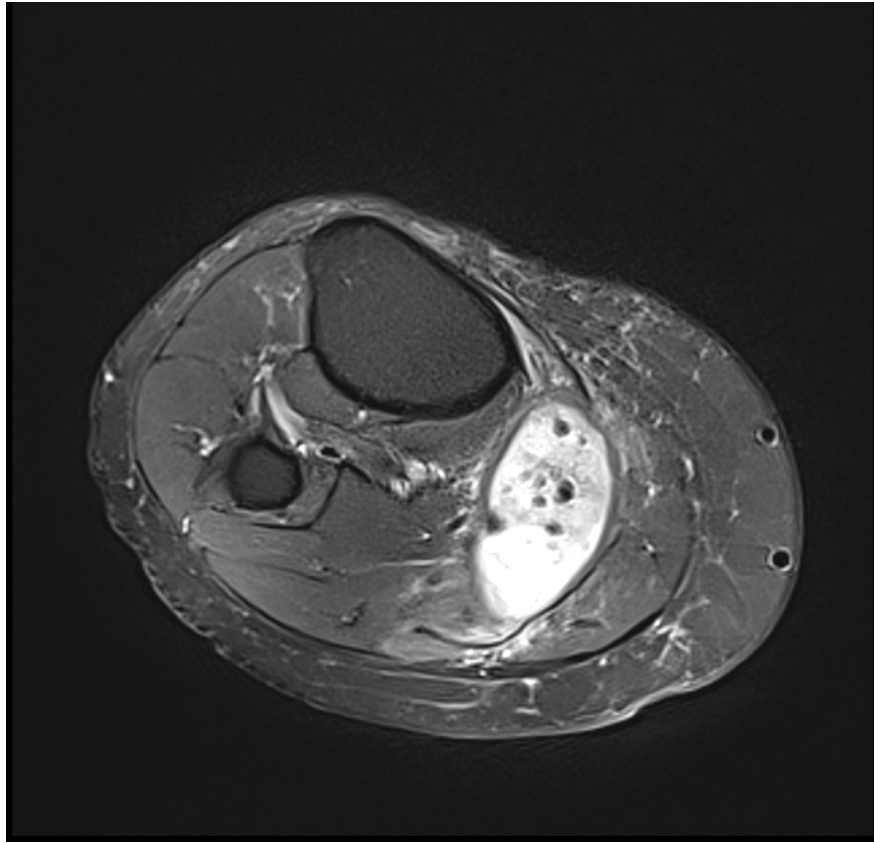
Axial T2 FS of the right knee showed a popliteal cyst containing multiple round hypointense foci - correlating to recent radiographic appearance of gas locules. There was no evidence of soft tissue inflammation to suggest infection.
